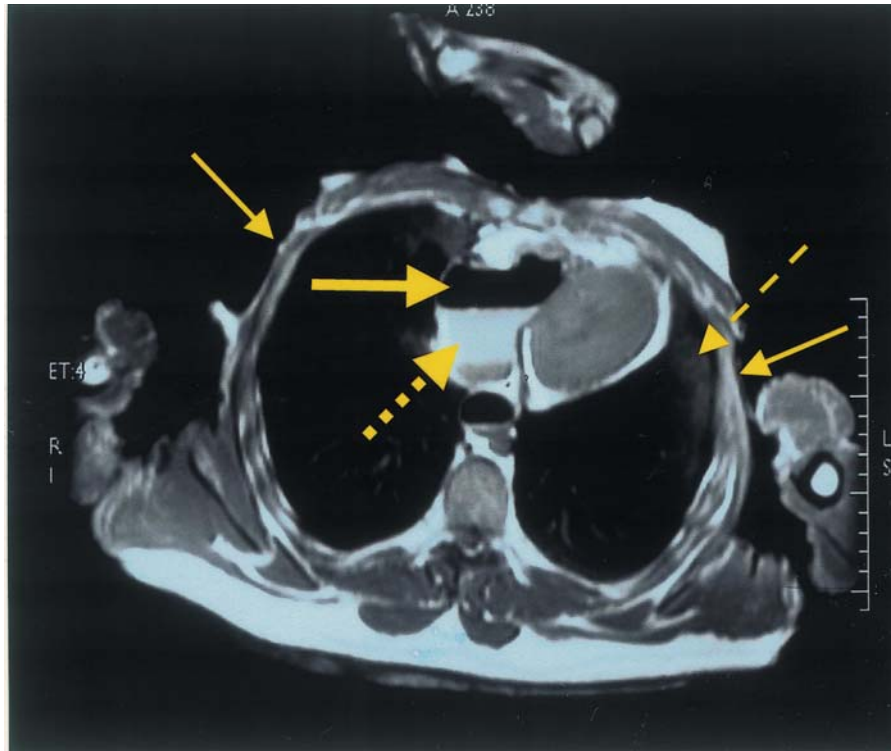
Burnt torso (Case 004). Varying degrees of carbonization as seen in the axial T1-weighted fast SE MR image (540/16). The ventral parts show partial loss of the signal-intensive layer of subcutaneous fat (thin arrows); contusion of the left lung (fragmented thin arrow); intracardial air embolism (bold arrow); trilayer sedimentation of blood components in the heart (fragmented bold arrow).
